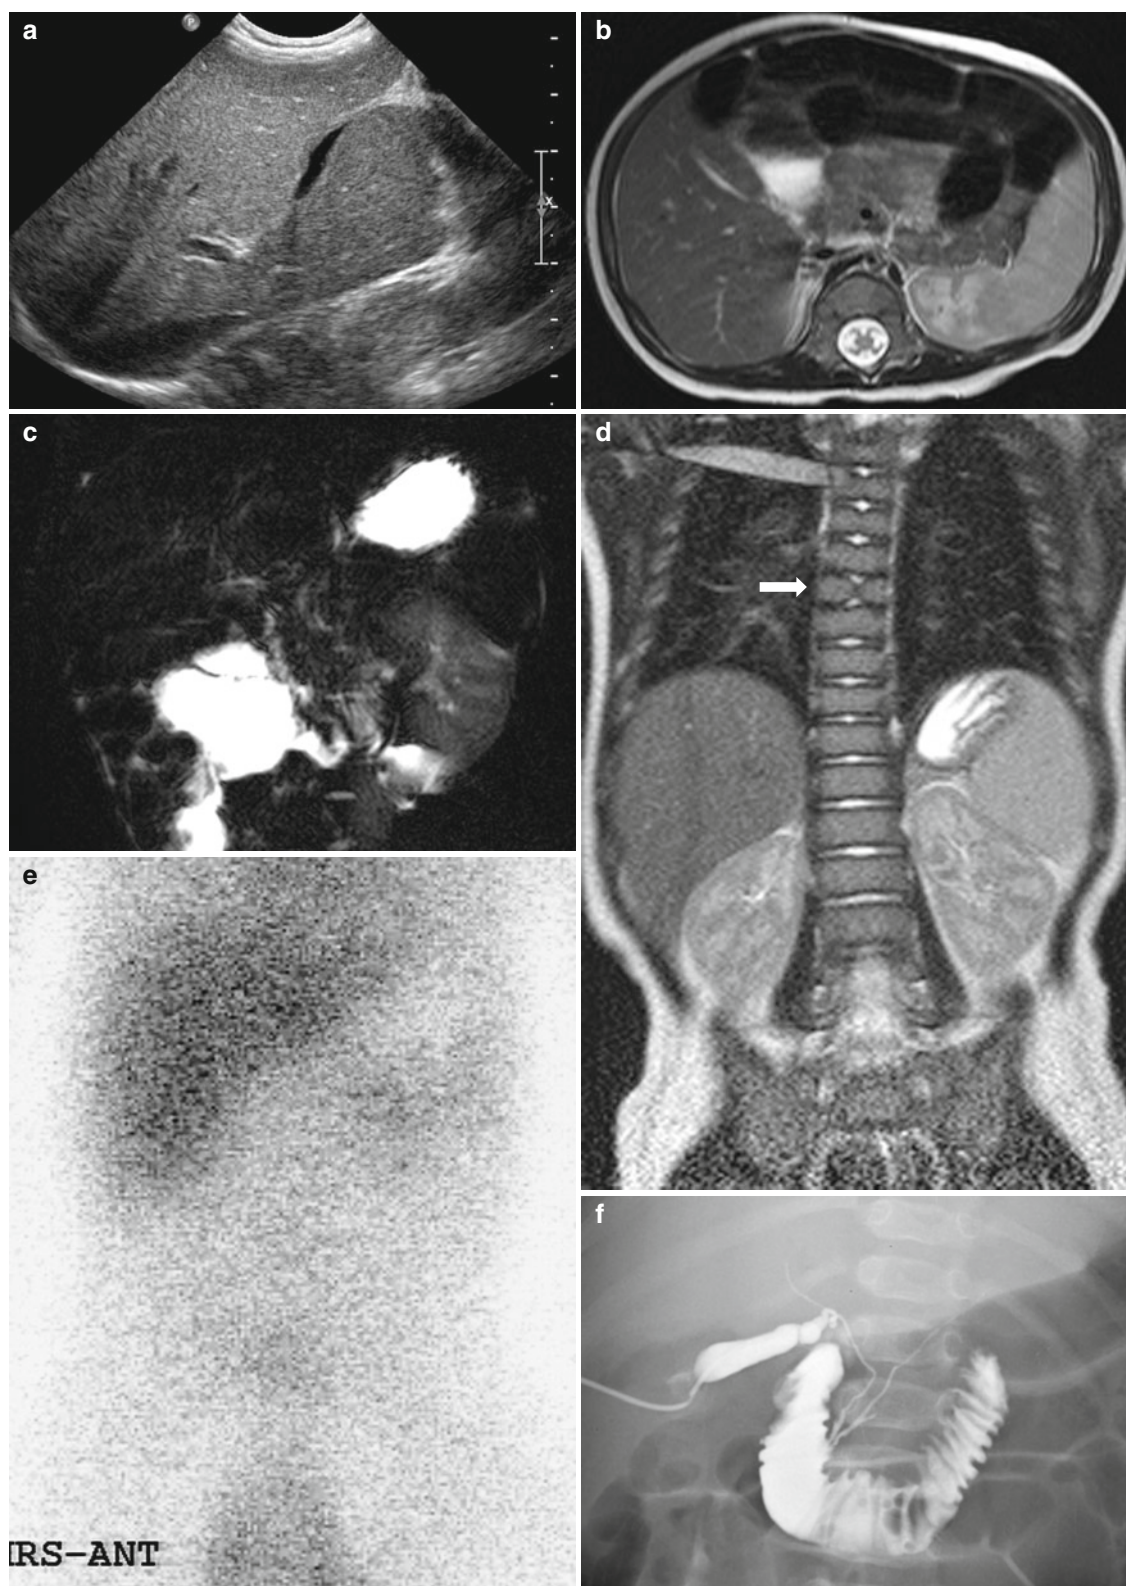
Alagille syndrome in a 5-month-old girl. (a) Abdominal US shows collapsed gallbladder without increased periportal echogenicity. (b) T2-weighted axial MR image also shows collapsed gallbladder without increased periportal signal intensity. (c) Two-dimensional T2-weighted MRCP does not demonstrate extrahepatic bile duct. (d)
